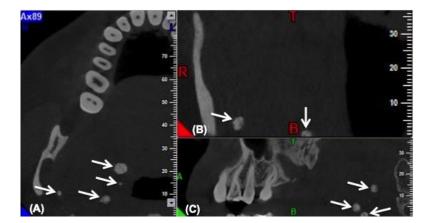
Axial (A), Coronal (B) and Sagittal (C) CBCT images showing multiple radiopaque structures at the right palatine tonsillar crypts level corresponding to tonsilloliths (white arrows).
